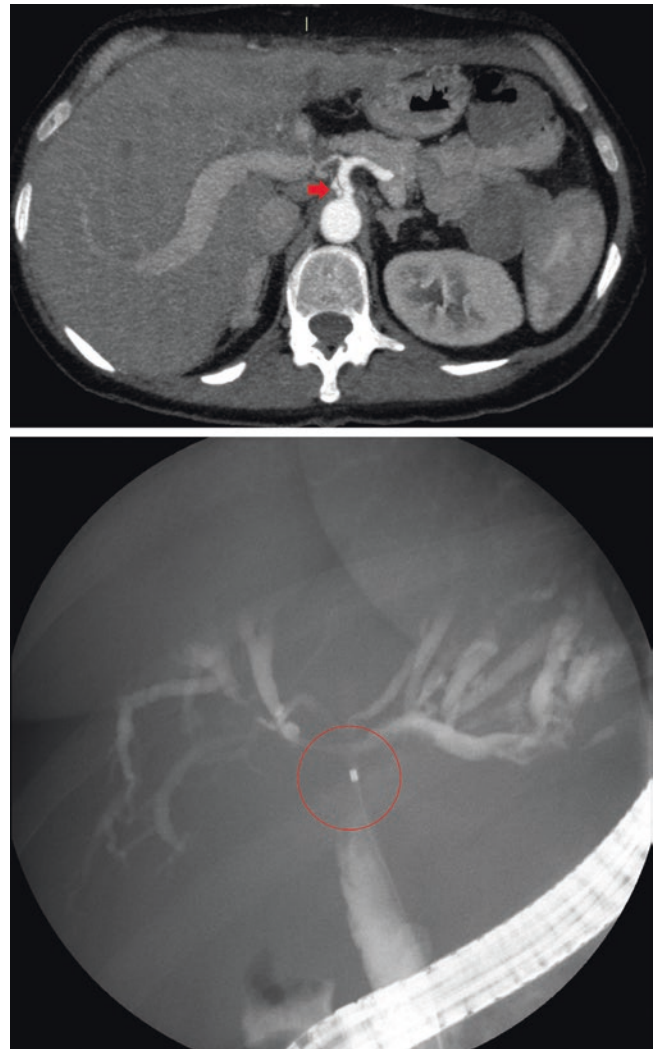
Top image—CT in the late arterial phase demonstrates normal filling of the coeliac trunk and splenic artery but abrupt truncation at the origin of the hepatic artery. A small flap is seen in the artery consistent with a dissection. Bottom image—ERCP performed 3 months later demonstrating an extensive stenosis at the liver hilum with dilated intrahepatic ducts—this is consistent with ischaemic cholangiopathy secondary to loss of hepatic artery
